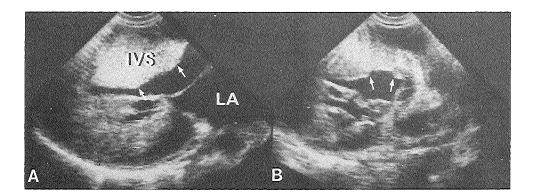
Intraoperative two-dimensional echocardiograms showing the results of left ventricular outflow tract myectomy in a patient with hypertrophic obstructive cardiomyopathy. The short-axis view (B) indicates its width and depth within the interventricular septum (IVS) (arrows). LA = left atrium.
